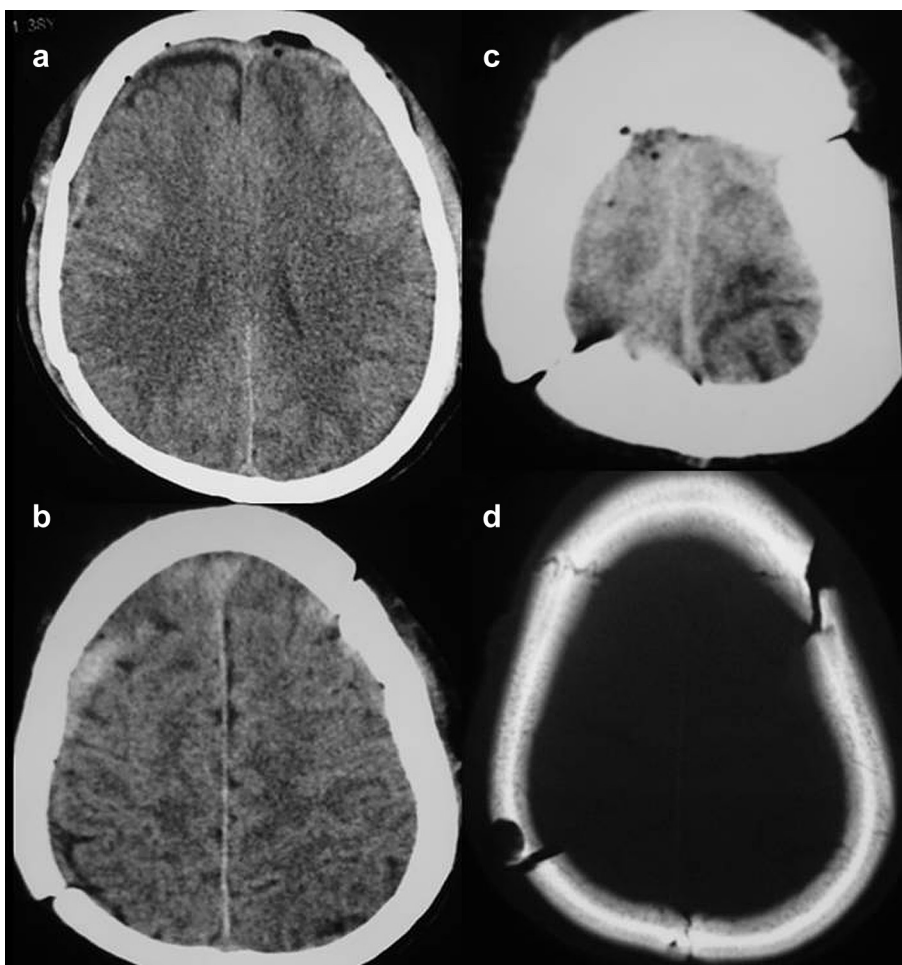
Post operative CT scan of head in axial cuts at three different level (a, b, c) with no residual extradural hematoma and mass effect and bone window (d) showing the burr hole site close to left side posterior parietal fracture and the fracture on opposite side.
